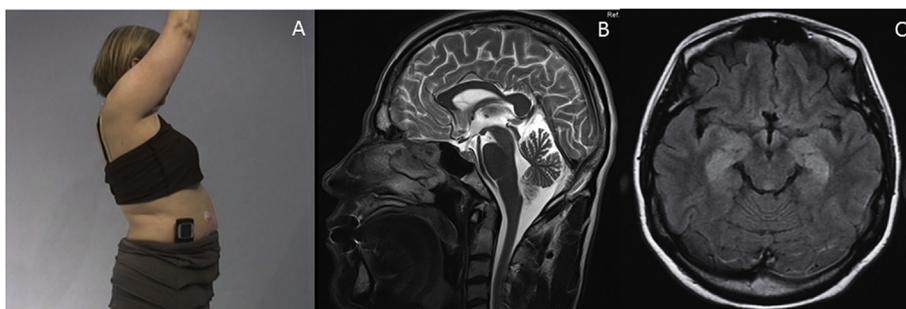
A) Typical hyper-lordotic posture of classical stiff-person syndrome. B) Sagittal MRI shows mild cerebellar atrophy in a patient with GAD associated gait ataxia; C) Axial MRI shows bilateral hyperintensities restricted to both temporal lobes, consistent with limbic encephalitis [C is reproduced with permission from Oxford University Press].
